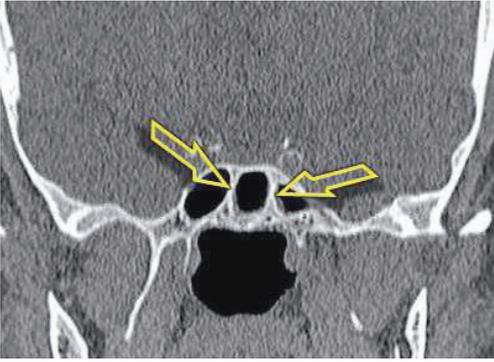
CT scan of the paranasal sinuses, frontal plane. Total number of septa — 2, total number of antra in the sphenoid sinuses — 3 (2/3).
